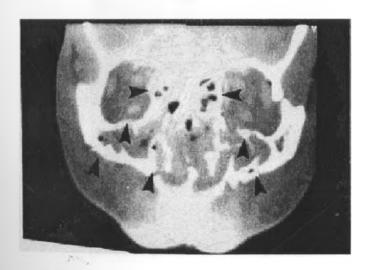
A coronal CT scan image of the face showing Le Forte 2 injury — fracture of maxilla inferior orbital wall, comminuted fracture of nasofrontal ethmoic region.
